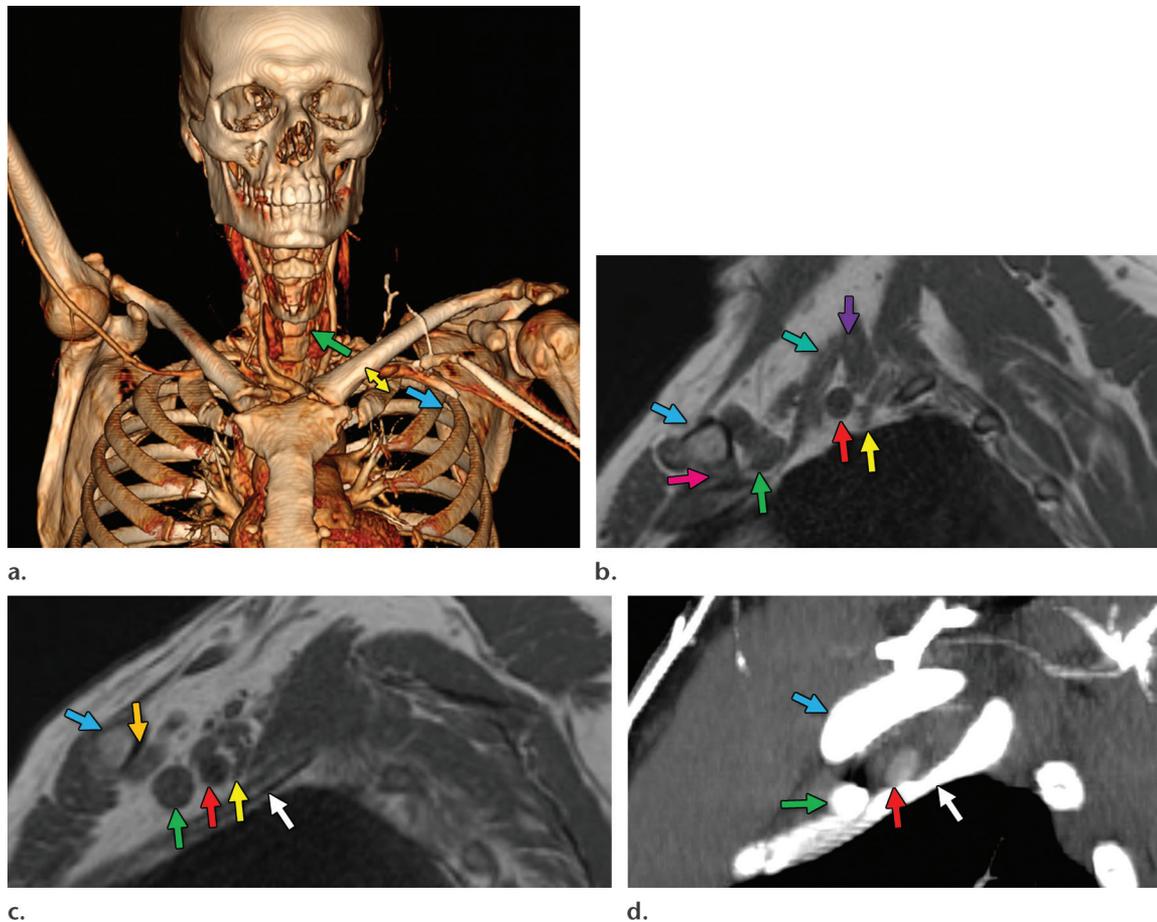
Cross-sectional anatomy of the thoracic outlet at computed tomography (CT) and magnetic resonance (MR) imaging. (a) Volumetric CT reconstruction shows the locations of the three compartments of the thoracic outlet. The scalene triangle lies above the clavicle (green arrow). Moving laterally, the costoclavicular space lies between the clavicle and first rib (double-headed yellow arrow). The most lateral compartment, the pectoralis minor space, lies inferior to the clavicle (blue arrow). (b) Sagittal T1-weighted MR image at the level of the scalene triangle with the arms adducted shows key structures at this level, including the middle scalene muscle (purple arrow), anterior scalene muscle (teal arrow), clavicle (blue arrow), costoclavicular ligament (pink arrow), subclavian vein (green arrow), subclavian artery (red arrow), and brachial plexus (yellow arrow). (c) Sagittal T1-weighted MR image at the level of the costoclavicular space with the arms adducted shows the clavicle (blue arrow), subclavius muscle (orange arrow), subclavian vein (green arrow), subclavian artery (red arrow), brachial plexus (yellow arrow), and first rib (white arrow). (d) Sagittal CT image of a different patient at the level of the costoclavicular space with the arms abducted shows how the clavicle (blue arrow) moves posteriorly over the neurovascular bundle, resulting in crowding of these structures. Green arrow = subclavian vein, red arrow = subclavian artery, white arrow = first rib.
